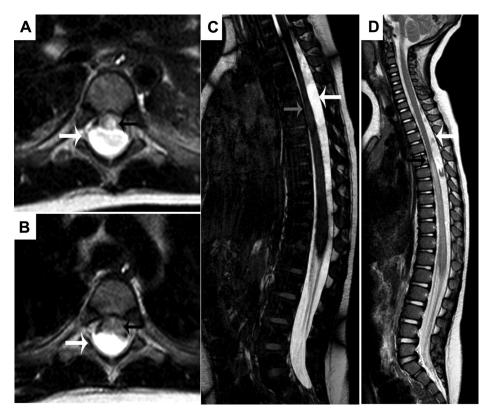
Axial (A, B) and sagittal (C, D) preoperative T2-weighted MR images demonstrate a dorsal fluid collection consistent with arachnoid cyst (White arrow) in the thoracic spine compressing the spinal cord with early spinal cord (Black/gray arrow) signal change.
